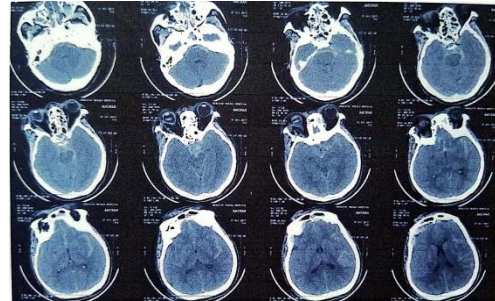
The first Head CT scan
